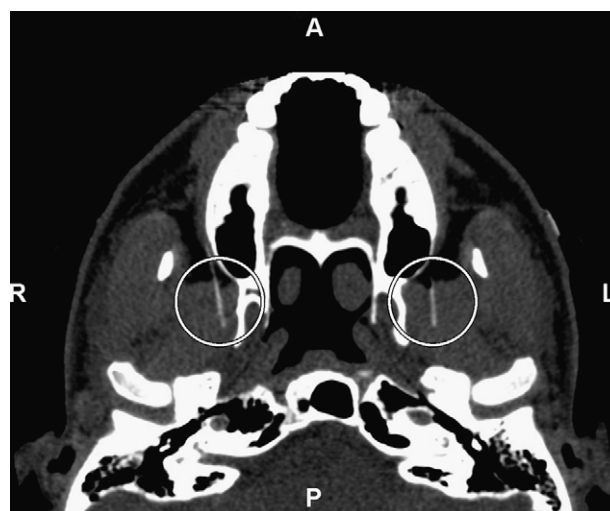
Verification of electrode placement by computed tomographic imaging. Horizontal slice showing anterior (A), left (L), right (R) and posterior (P) aspects, and fine-wire electrode tips (circled) within inferior head of right and left lateral pterygoid muscles in one subject.
